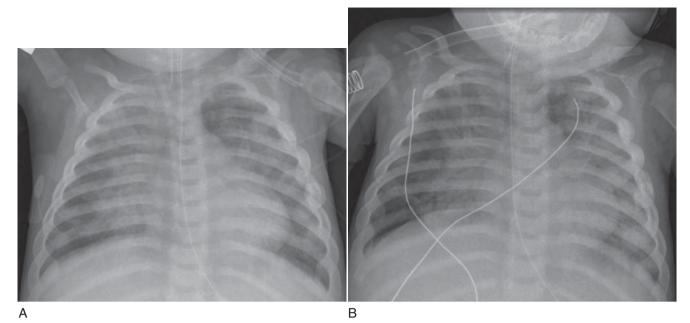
A, Chest radiograph of a 13-month-old, 2 hours after fresh water immersion, showing extensive, mainly perihilar, airspace opacities. B, Chest radiograph of the same patient, 24 hours later, showing some clearing of the pulmonary edema.
